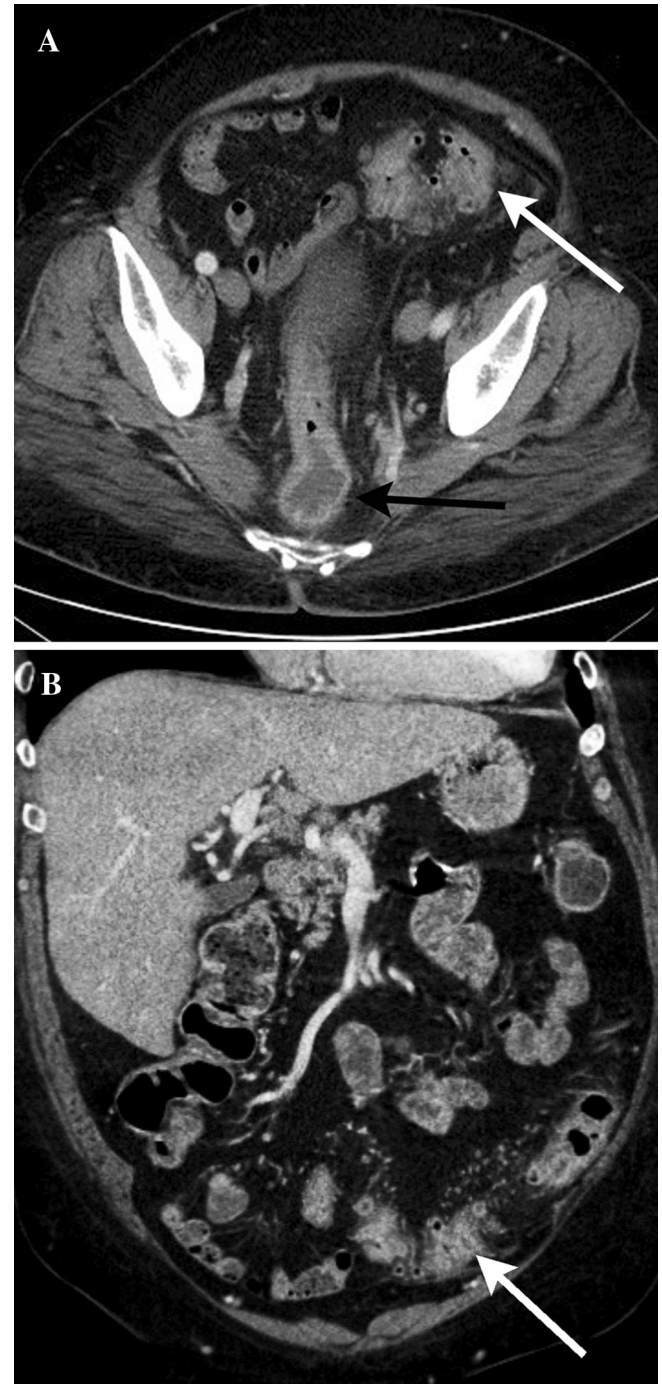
Transverse (A) and coronal reformation (B) CT images in a 71-year-old male with segmental colitis with associated diverticulosis pattern. There is colonic wall thickening (*white arrow*), pericolic fat stranding, mesenteric vessel engorgement, and mucosal hyperenhancement involving the recto-sigmoid colon, a segment of colon with diverticulosis.
